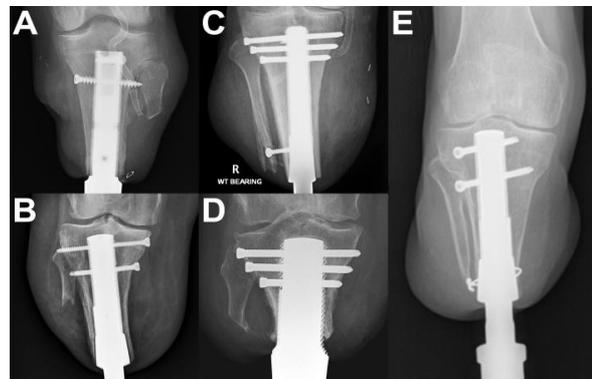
Representative radiographs of the operated limb containing the osseointegrated implant, taken at 12 months post-operation for the five patients.
